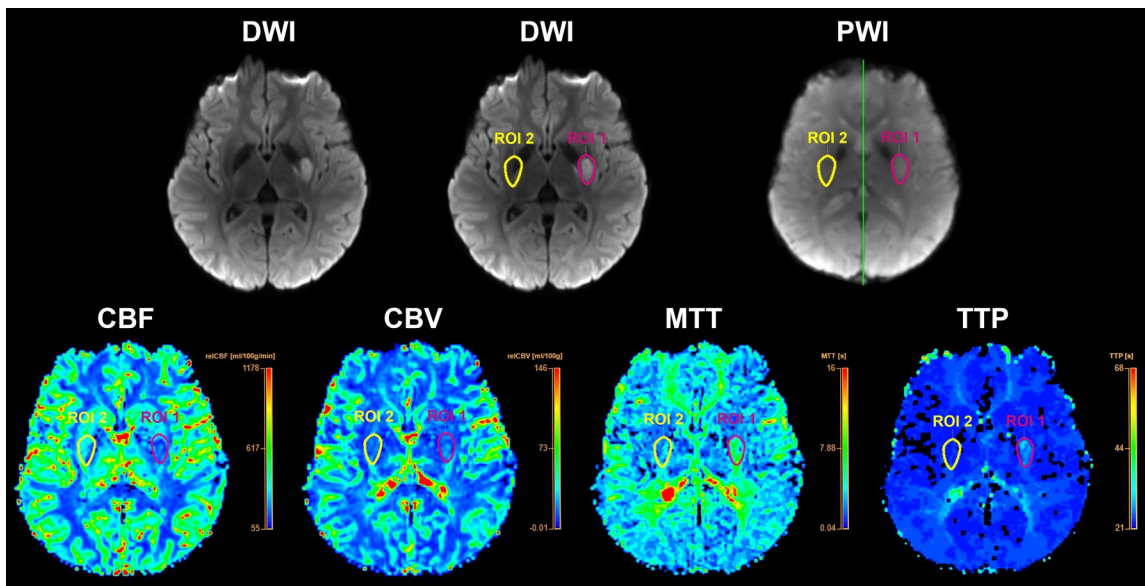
Co-registration of imaging and definition of regions of interest (ROIs). An ROI was defined on the acute infarction in the DWI map (ROI 1) and mirrored to the contralateral unaffected hemisphere (ROI 2). Then, each ROI was automatically co-registered onto the perfusion maps of cerebral blood flow (CBF), cerebral blood volume (CBV), mean transit time (MTT), and time to peak (TTP). The relative CBF, CBV, MTT, and TTP values of the infarct lesion were calculated as the ratio of ROI 1 to ROI 2. The green line represents the midline.
